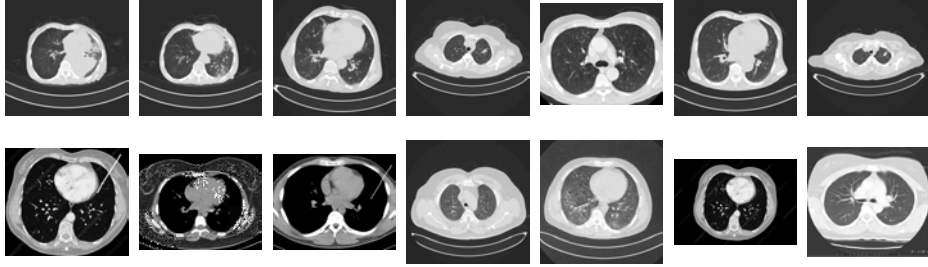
Sample lung CT images: Top row shows malignant cases, bottom row shows normal cases.
